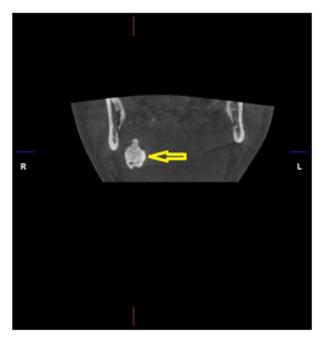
Coronal section of CBCT showing Right Submandibular sialolith (*Photo courtesy:* Buch SA, Babu SG, Hegde S, Rao S, Ajila V. CBCT Imaging of a Giant Sialolith (Megalith). Journal of Dentistry, Oral Disorders & Therapy [Internet]. 2019 Mar 11;7(1)
